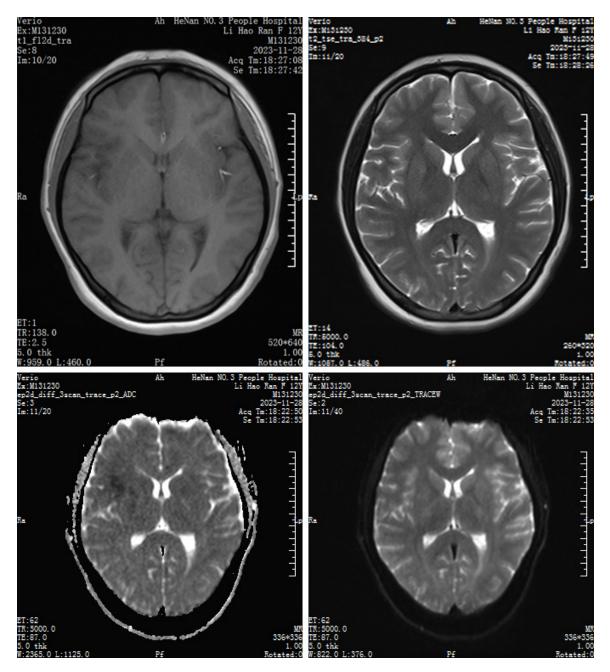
Nuclear magnetic resonance imaging. No abnormal signs were found on T1 or T2 MR images, but patchy abnormal signals were observed in the right insular lobe on DWI and ADC imaging equences, which was consistent with the diagnosis of acute cerebral infarction.
